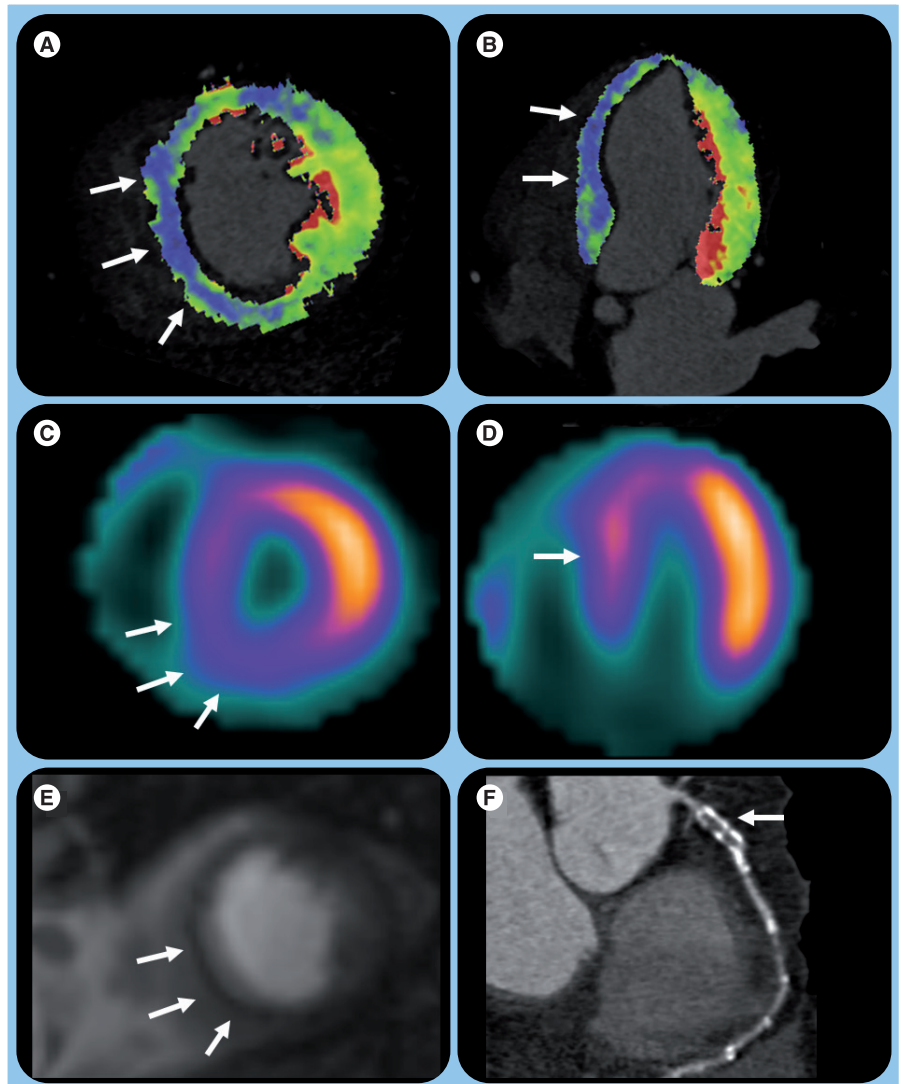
Dynamic real-time myocardial stress-perfusion in a 50-year-old man presenting with atypical chest pain using second-generation dual-source computed tomography. (A & B) The absolute quantification of the myocardial perfusion and resulting computed tomography (CT) myocardial blood pool perfusion maps reveal hypo-perfusion (blue color, labeled with arrows) most prominent inferoseptally in the mid-ventricular portion of the left ventricle with decreased myocardial blood flow of approximately 60 ml/100 ml/min. (C & D) CT findings were confirmed by SPECT and (E) stress-perfusion MRI. (F) Curved multiplanar reformat depicting a calcified and noncalcified plaque, causing occlusion of the proximal right coronary artery.
